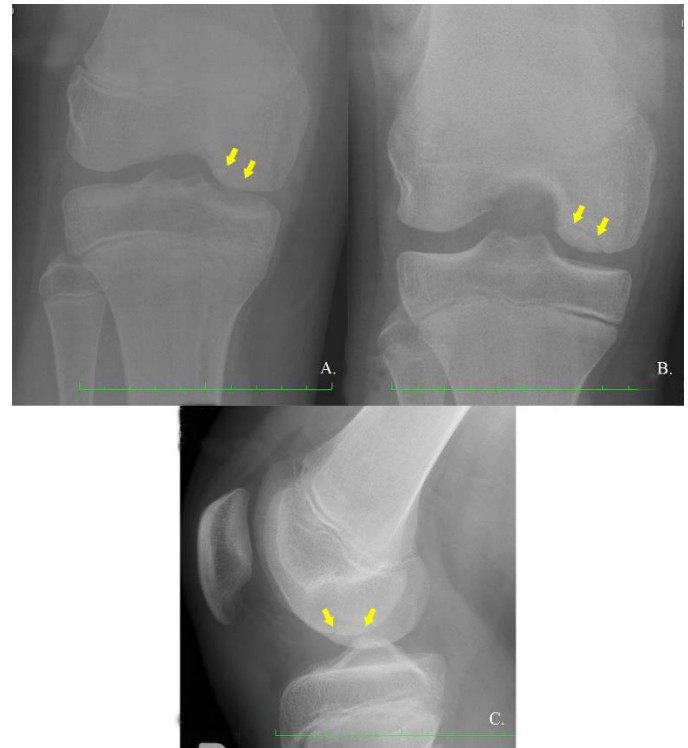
Radiographs showing medial femoral condyle OCD lesion on AP (A), Tunnel (B), and Lateral (C) views (yellow arrows).
